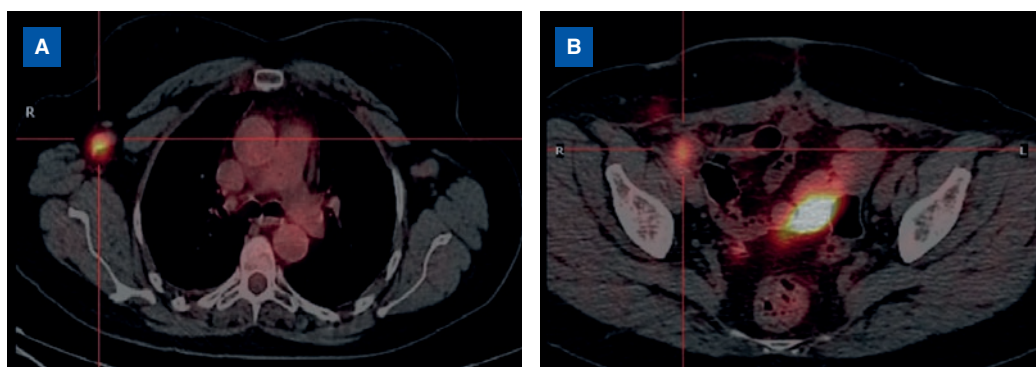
Positron emission tomography-computed tomography (April 2017): axillary lymphadenopathies in the common right iliac system, the external iliac systems, and inguinal regions, enlarged in size and with an increase in metabolic activity suspected as malignant.
